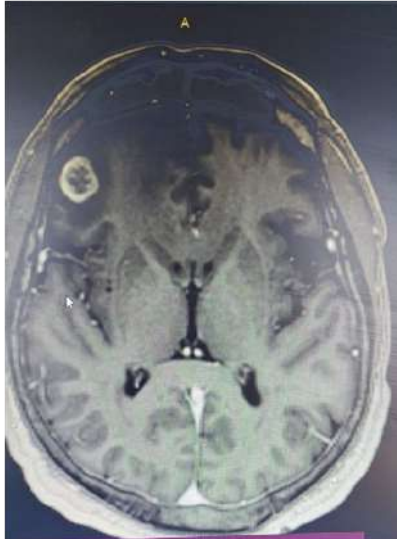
MRI, Patient 2, before surgery
